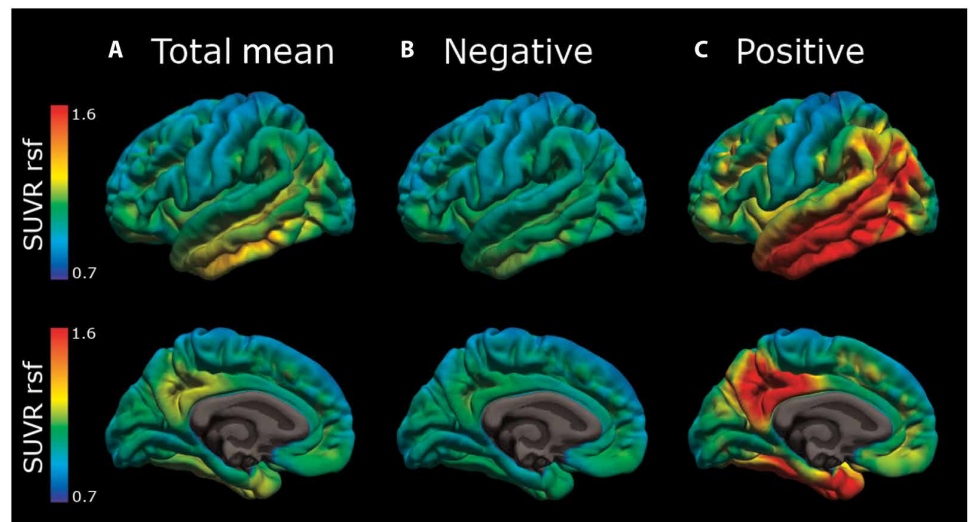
Mean tau pathology for the 38 participants with PET imaging. Mean AV-1451 tau pathology in (A) all, (B) tau-negative, and (C) tau-positive subjects as measured in SUVR units after partial volume correction using a regional spread function.
